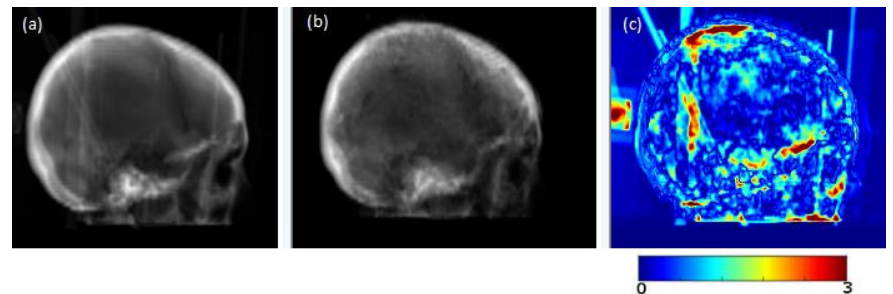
(a) Lateral DRRs from CT, (b) from sCT, (c)  $\gamma$  (DTA = 2mm,  $\Delta I = 5\%$ ) map with reference CT-based DRR
